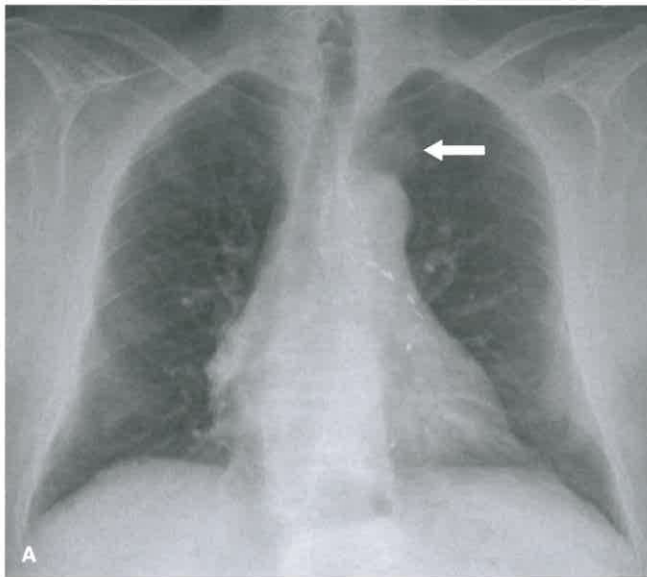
Tortuous Left Common Carotid Artery Producing Superior Mediastinal “Mass.” A: Chest radiograph demonstrates a left superior mediastinal mass (*arrow*). B and C: Axial (B) and coronal (C) contrast-enhanced scans show a tortuous left common carotid artery arising from the aortic arch (*arrows* in B and C) as producing the “mass.”
